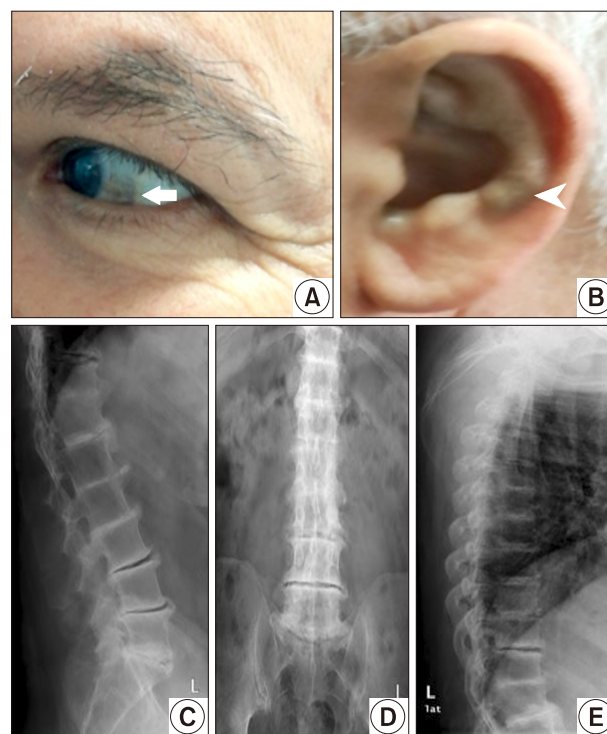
Photographs show blue-black pigmentation of the sclera (arrow) (A) and ear pinna (arrowhead) (B), X-ray of the thoracolumbar spine, multilevel intervertebral disc space narrowing associated with disc calcifications (C~E). We received the patient's consent form about publishing all photographic materials.
